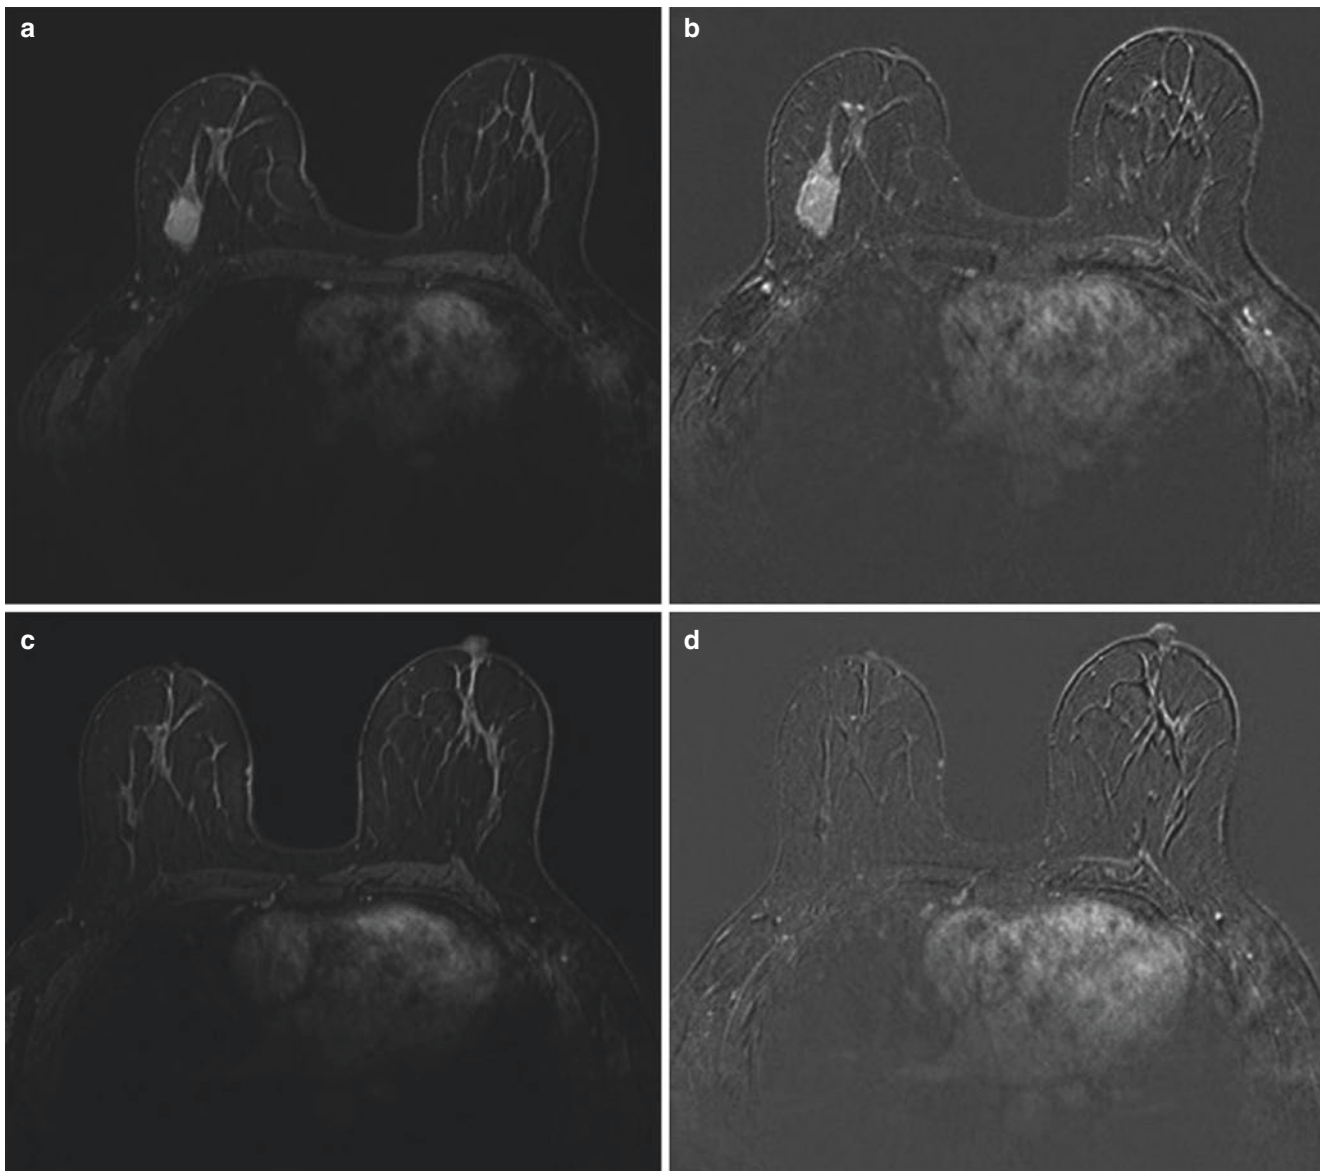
Magnetic resonance imaging of the patient with a mass in her right breast. (a, b) Before PST. (c, d) After PST with complete pathological response
